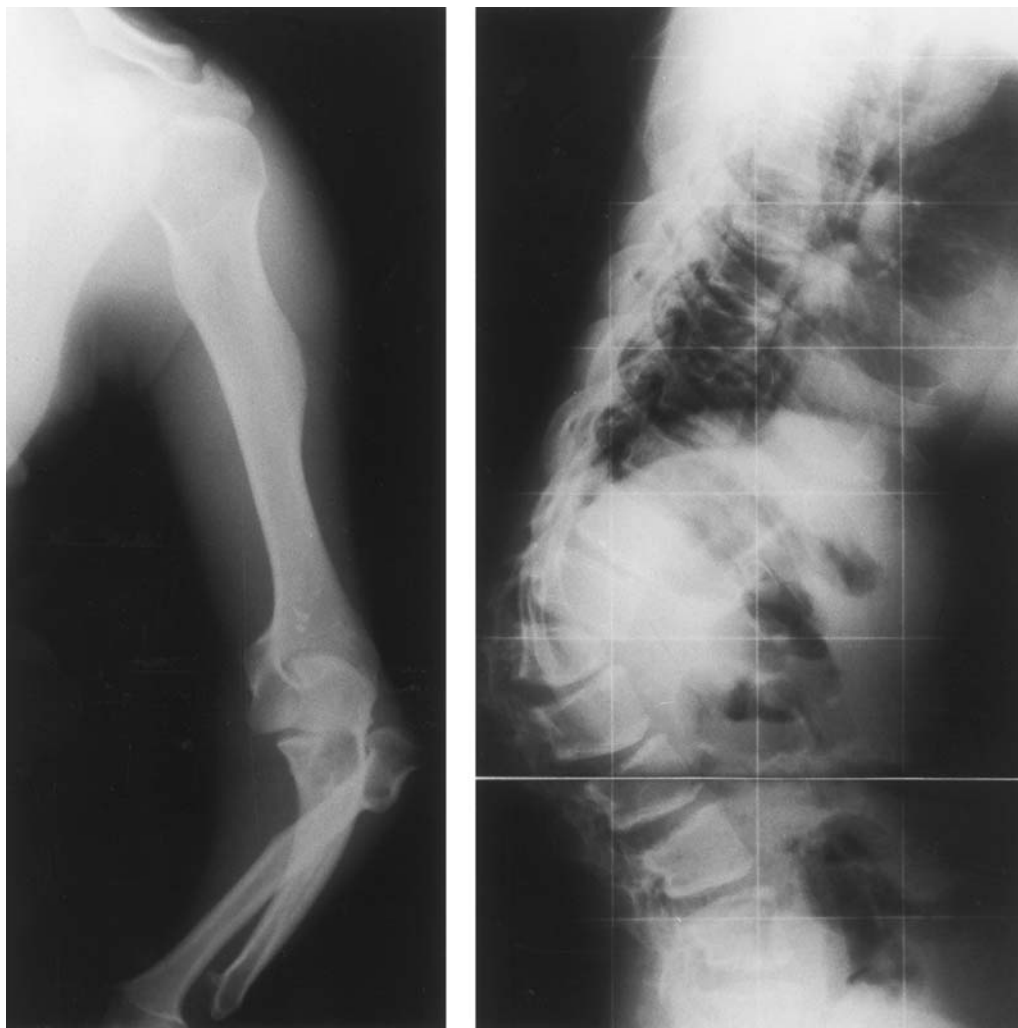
X-rays for individual IV:10. Note shortening of the tubular bones in the upper extremity (*left*), with disproportionate shortening of the radius and ulna in comparison with the humerus; the radial head is also luxated. Lateral X-ray of the spine (*right*) reveals anterior hypoplasia of the first lumbar vertebral body, whereas the second to fifth lumbar vertebral bodies are wedge shaped, with the dorsal margins shorter than the ventral margins.
